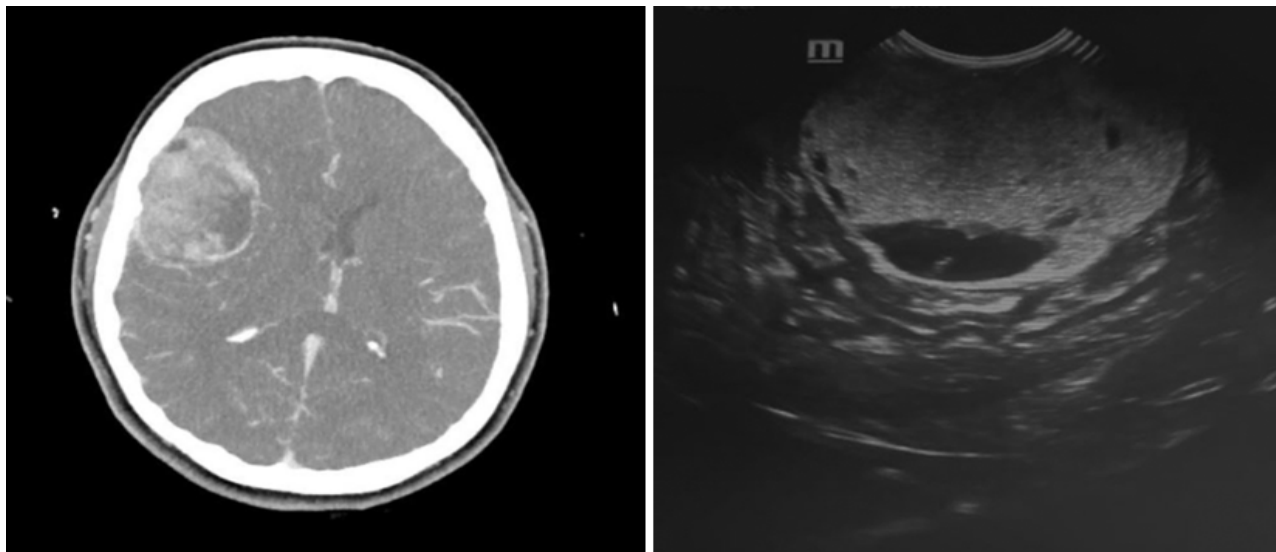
Figure 1 and 2 are CT scan with contrast image of a right convexity meningioma and a corresponding IoUS image of the same tumour.
